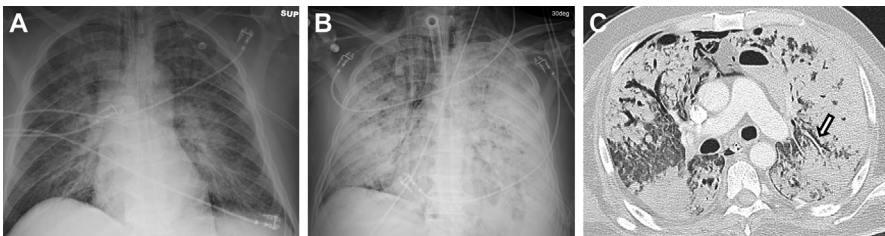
Progression of hantavirus to ARDS in a 54-year-old man. (A) AP chest radiograph demonstrates bilateral perihilar hazy opacities in a "bat wing," pattern as well as Kerley B lines, with normal size of the cardiac silhouette and no pleural effusions. (B) AP frontal chest radiograph 3 days later demonstrates extensive bilateral consolidation and hazy opacities which obscure the cardiac silhouette. There is a small right pneumothorax, and lucencies along the right mediastinum and right heart border representing pneumomediastinum. ECMO cannula is in place. (C) Chest CT shows extensive bilateral consolidation. Pneumomediastinum and Macklin effect in the left lower lobe suggest barotrauma (arrow).
